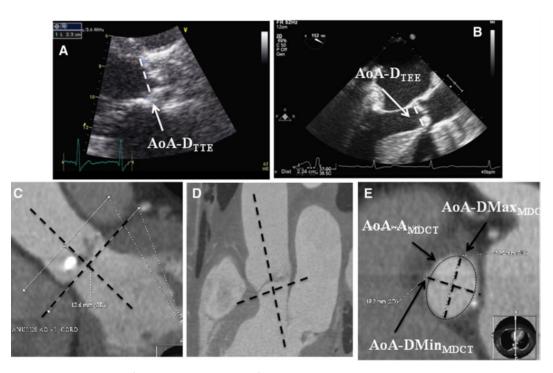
Methodology for the assessment of the AoA. A, TTE: the AoA-D was measured in midsystole by TTE (AoA-D_{TTE}) in a parasternal long-axis view on the left ventricular outflow tract at the point of insertion of the right and non-coronary aortic leaflets. B, TEE: the AoA-D was measured in mid-systole by TEE (AoA-D_{TEE}) in the mid-esophageal long-axis view (120° to 140°) on the left ventricular outflow tract at the point of insertion of the right and non-coronary aortic leaflets. C-E, MDCT: the AoA evaluated by MDCT (AoA_{MDCT}) was defined as a virtual ring formed by joining the basal attachments of the aortic leaflets. AoA_{MDCT} maximum diameter (AoA-DMax_{MDCT}), minimum diameter (AoA-DMin_{MDCT}) and area (AoA-A_{MDCT}) were measured in an orthogonal plane on the center-line of the aorta obtained in oblique coronal and oblique sagital views, respectively.
